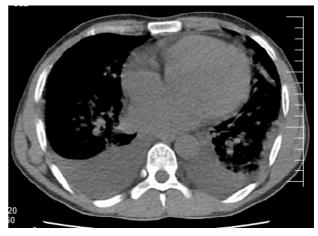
Bilateral alveolar hemorrhage in CT-Scan
